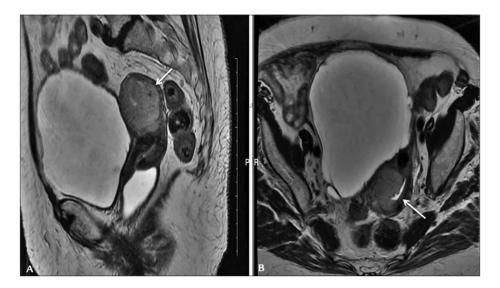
Imaging findings: T2-weighted MRI sequence on sagittal (A) and axial (B) views shows endometrial cavity occupied by slightly hyperintense mass compared to the myometrium, and extension to the right lateral wall of the uterine body (arrow).
